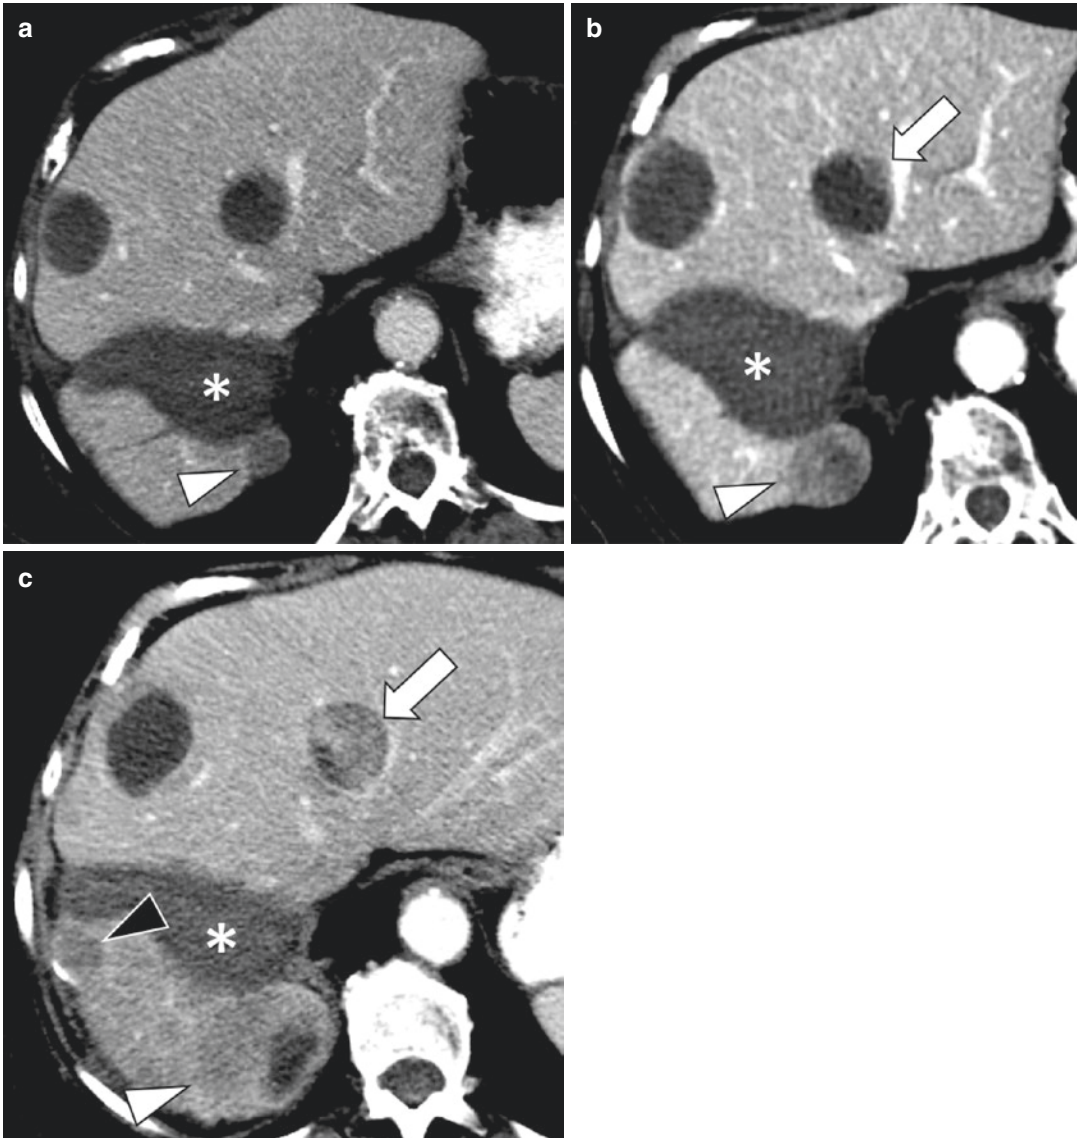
76-year-old female with history of GIST metastatic to liver, previously treated with hepatic resection and ablation, currently off therapy. (a) Axial contrast-enhanced CT image obtained during surveillance demonstrates a cystic-appearing lesion in the liver which likely represent treated metastases. A large ablation zone is seen in the right lobe (asterisk). A hypodense lesion posterior to the ablation zone (white arrowhead) was suspicious for recurrence. (b) Follow-up CT obtained 1 month later shows enlargement of the lesion posterior to the ablation
